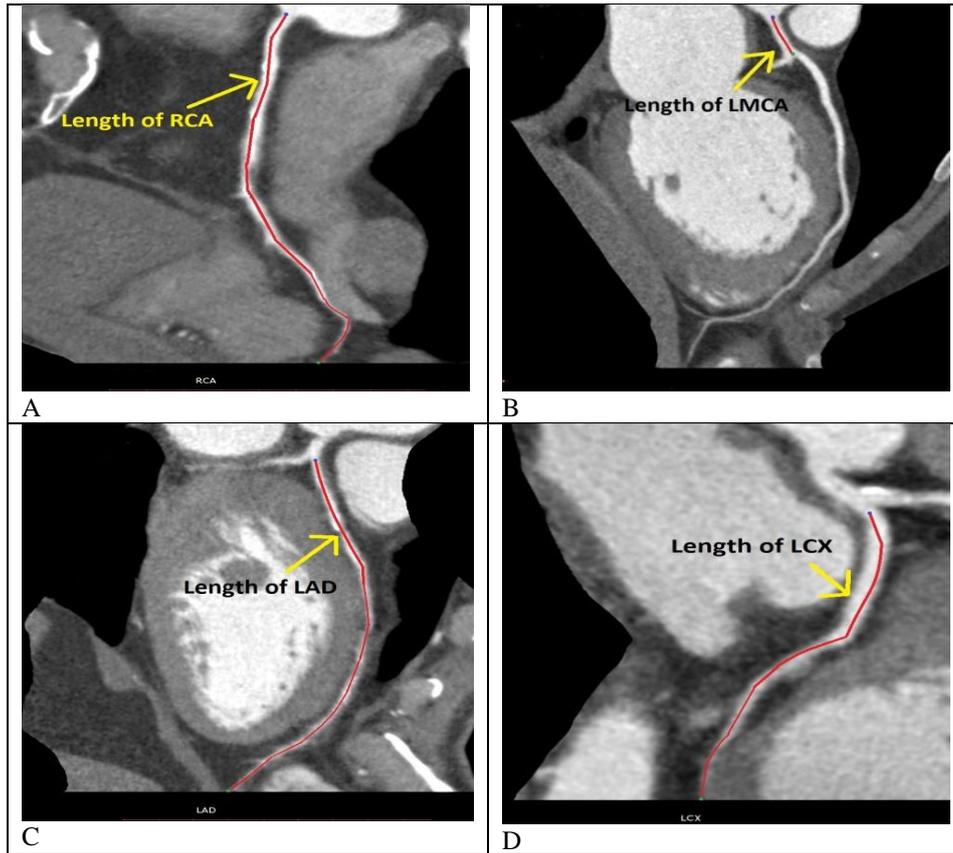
Photograph of coronary CT angiogram (Curved multiplanar view) showing length of A) Right coronary artery. (RCA: Right coronary artery); B) Left main coronary artery. (LMCA: Left main coronary artery); C) Left anterior descending artery. (LAD: Left anterior descending artery); D) Left circumflex artery. (LCX: Left circumflex artery)
